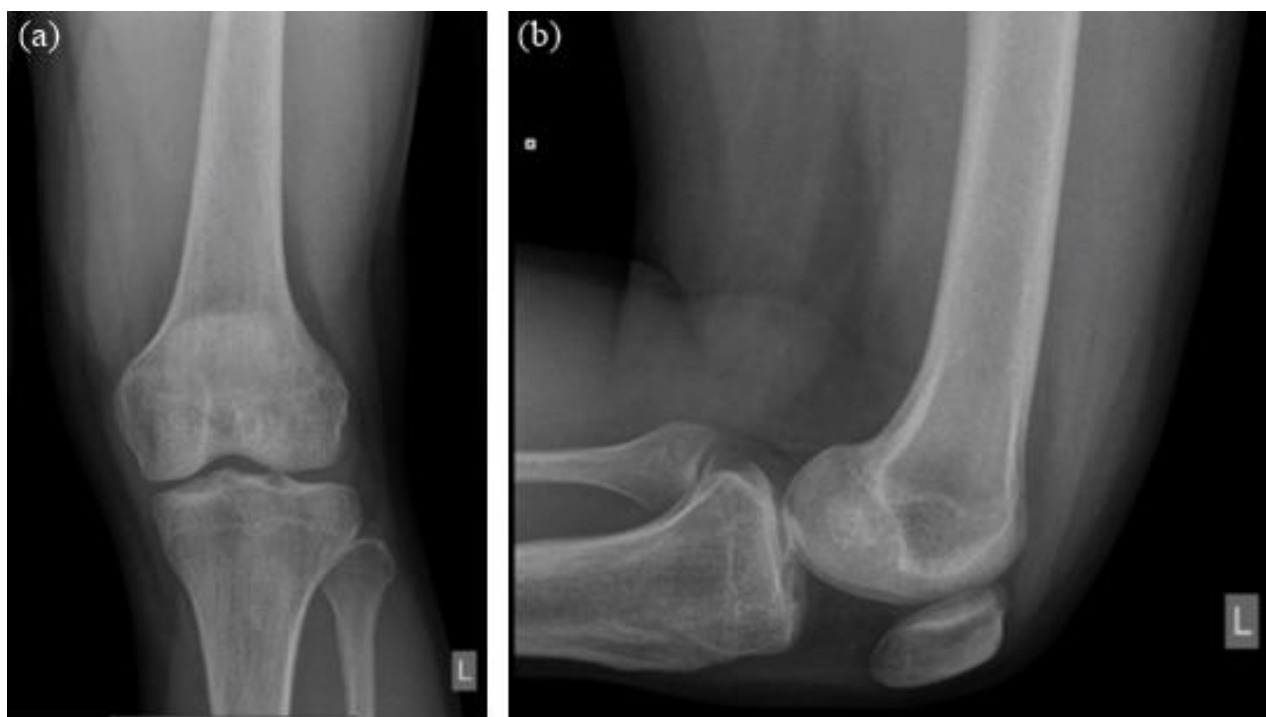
Radiograph (a, anteroposterior; b, lateral) of the left knee showing no apparent abnormalities.
